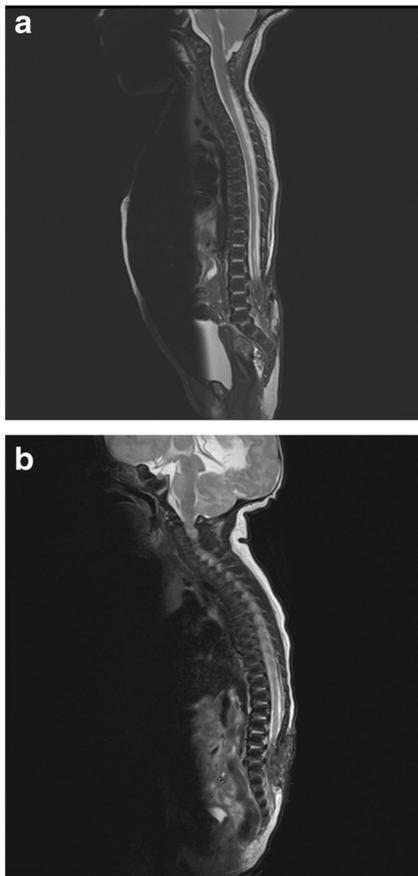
Spinocranial MRI after MMC repair, on the day of VP shunt implantation in the girl (a) and 7 days after VP implantation in the boy (b) showing sound closure of the MMC. The Arnold-Chiari malformation type II persists in the girl and is no longer seen in the boy
